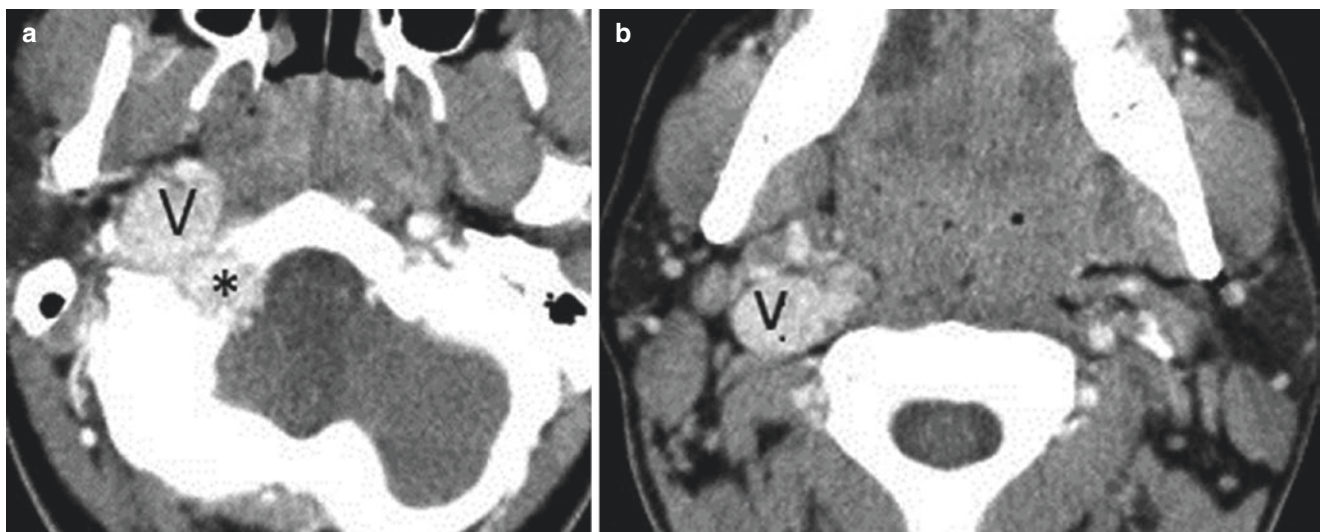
(a, b) Glomus jugulare. Axial enhanced CT images show a vascular avidly enhancing mass in the jugular foramen (*), with direct inferior growth into the internal jugular vein (V)
